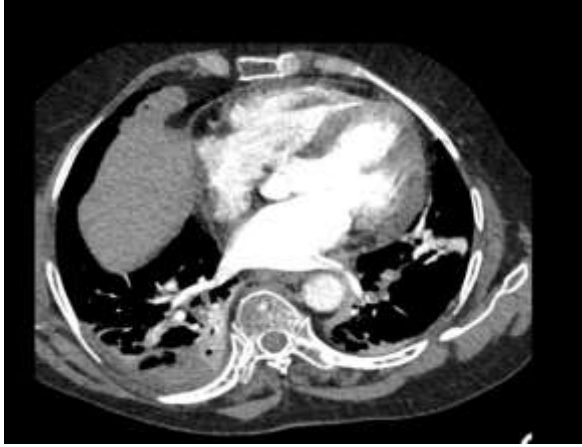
Contrast-enhanced CT image demonstrates intraluminal filling defect within the left lower pulmonary vein with extension into the left atrium.
